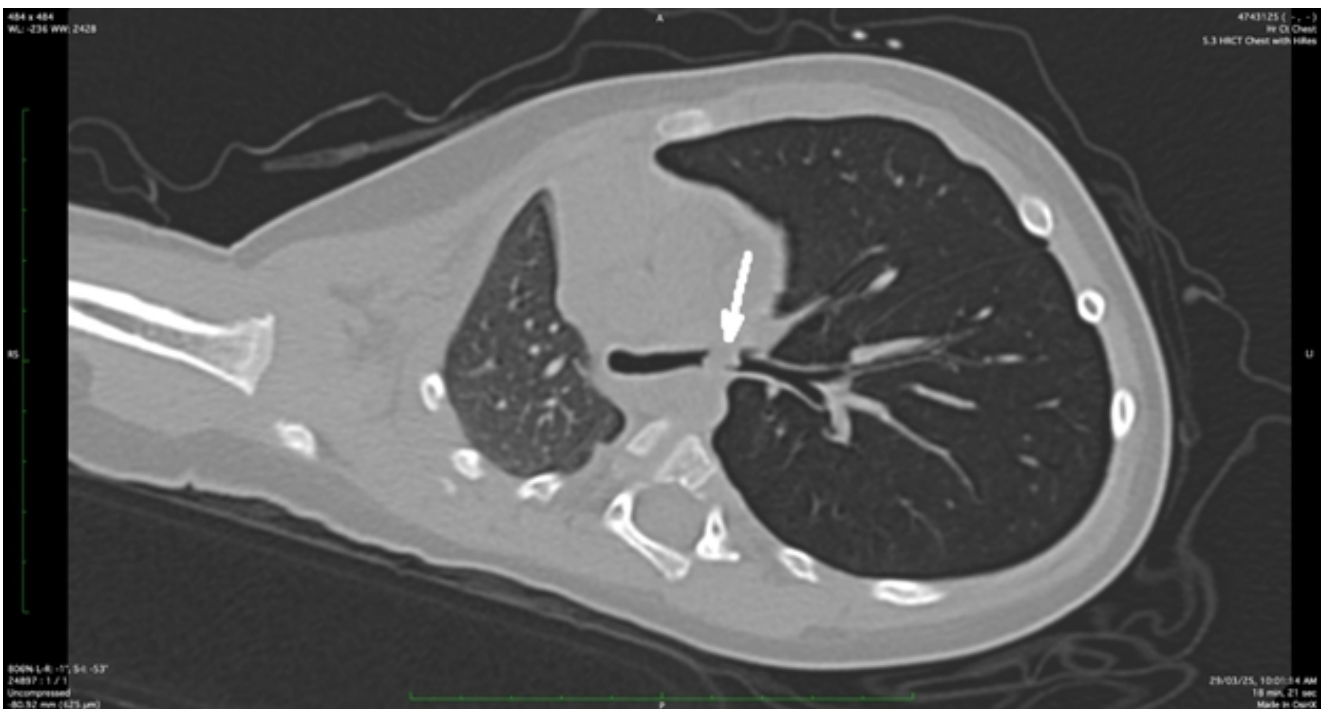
Axial View CT Chest showing Foreign Body in Left Main Bronchus and Obstructive Emphysema
